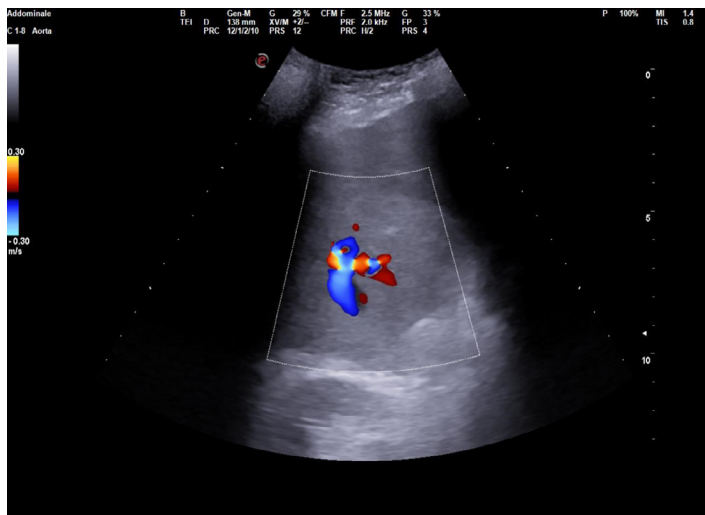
Abdominal Ultrasound (US) image of liver acquired using Eco-Color-Doppler showing an intrahepatic porto-systemic shunt presenting with anomalous connection between a branch of the portal vein and a branch of the hepatic vein.
